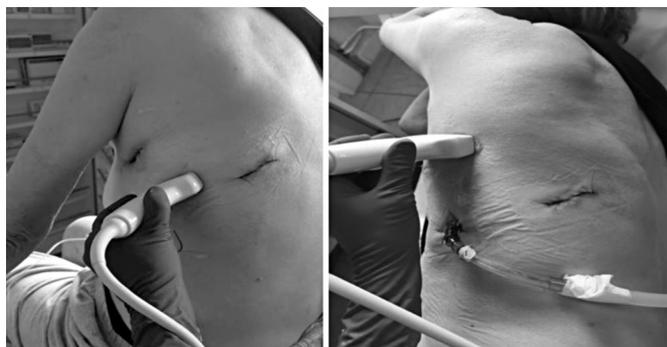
CUS performed in sitting patient's position (intercostal) and supine (basal pleura diaphragm). All scans were performed exploring the entire chest anteriorly, laterally and posteriorly, along parasternal, mid-clavicular, anterior, posterior and paraspinal axillary lines. CUS: chest ultrasound.
